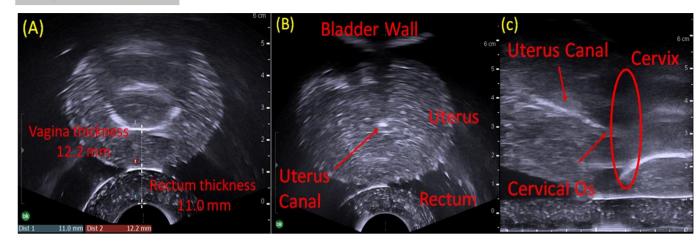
(A). Geometry verification on rectum and vagian wall thickness. Figure 4(B) Axial cross-section of uterus taken with a transrectal ultrasound probe. The uterus and rectum wall show up clearly. The uterus canal shows up as bright line on the US. The bladder wall is also distinguishable. Figure 4(C) shows longitudinal view of the ultrasound image, and the junction between vagina, cervix and uterus.
